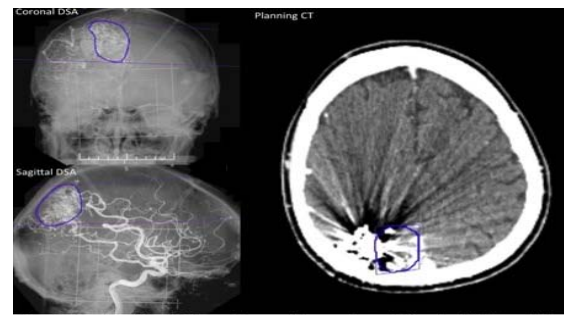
Overview of AngioFusion workspace with coronal (upper left) and sagittal (lower left) DSA datasets registered with the planning CT (right). Contours drawn on one imageset is automatically projected on the other data sets.
